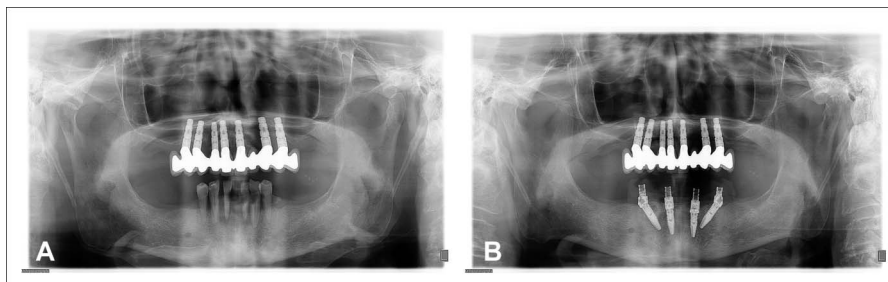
Maxillary edentulous ridge (A); panoramic radiograph after implant placement (B).
